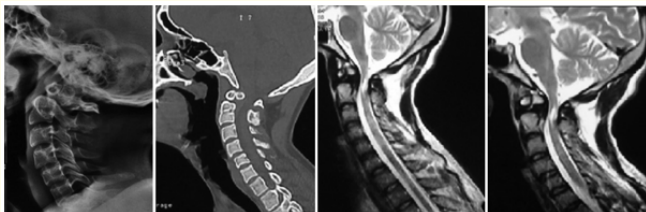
(a) Lateral Cervical spine X ray shows Os odontoideum with posterior atlanto axial dislocation. (b) Computed tomography cervical spine sagittal section shows C1 arch and Os odontoideum displacement with significant canal compromise. (c and d) Magnetic resonance imaging T2 weighted image sagittal section depicts compression at craniovertebral junction along with T2 hyper intense changes in the spinal cord suggestive of cord contusions. Anterior arch of C1 with Os odontoideum are displaced posteriorly over a foreshortened axis vertebrae.
